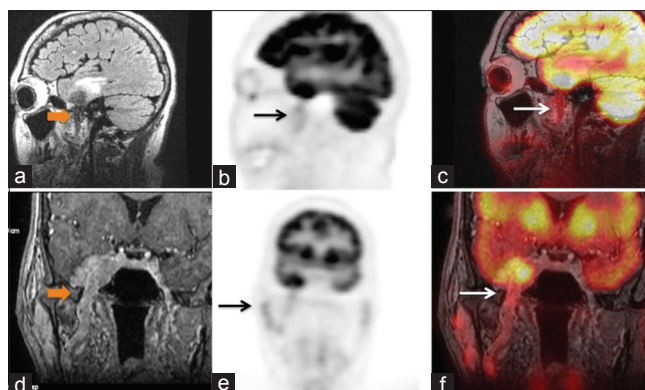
Sagittal MR [bold orange arrow (a)] showed hypointense signal in the lesion extending from the MCF along the V nerve, with sagittal FDG-PET (b) and fused PET/MRI (c) showing increased curvilinear FDG uptake in the lesion. Coronal MR (d), coronal FDG-PET (e), and fused PET/MR image (f) showed the contiguous perineural spread (PNS) of the lesion from the right parotid up to the right paracavernous region
